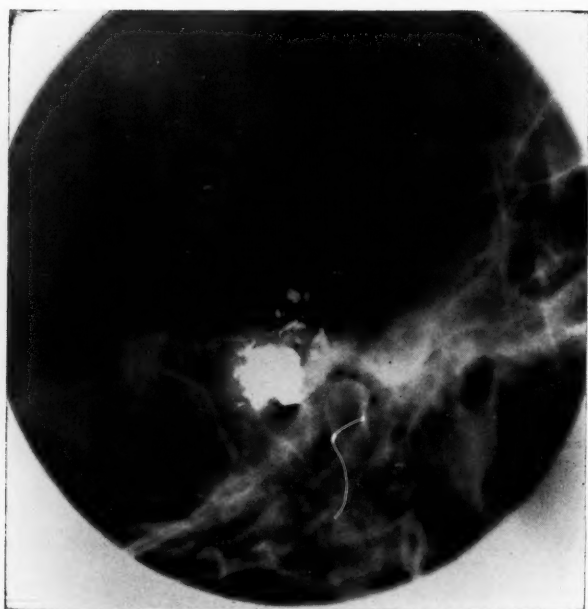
Case 2.—Roentgenogram left lateral view. Bullet fragments in the temporal bone.
